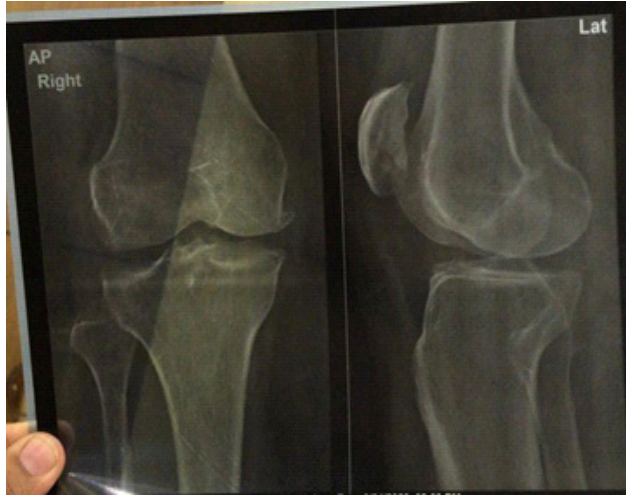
Right Knee X-Ray with Anterio-Posterior View & Lateral View
